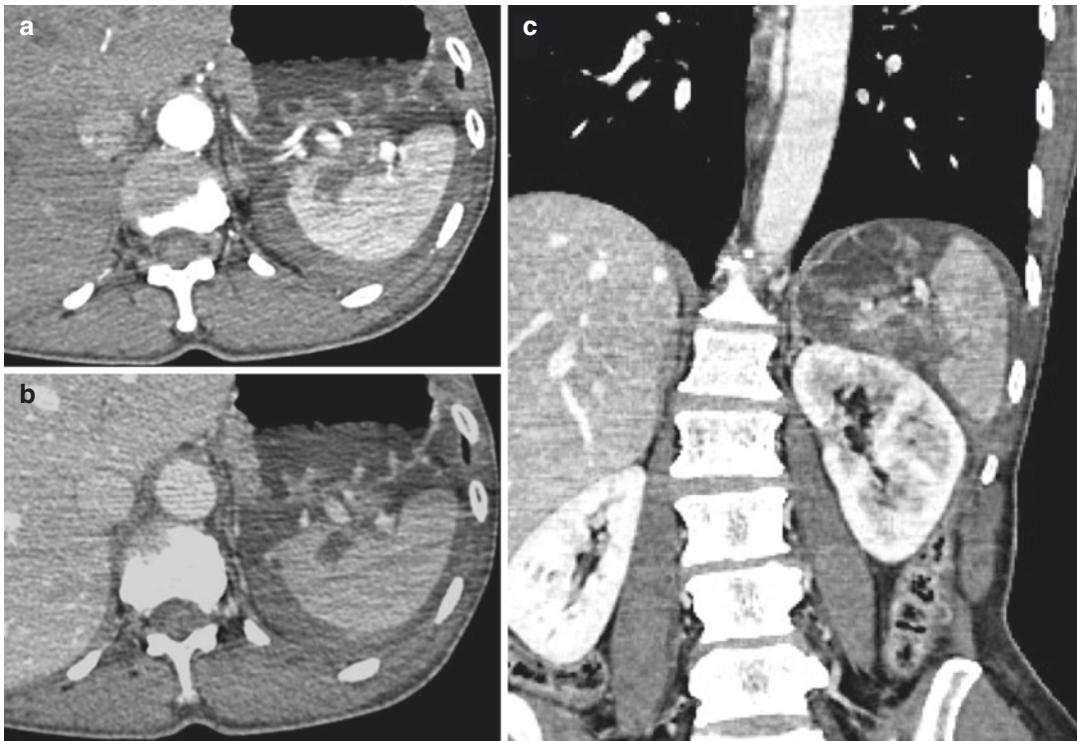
Grade 3: These CT images show a deep hilar splenic laceration with rupture of the capsule. Multiphasic CT scans in arterial (a-c) and venous phase in (b)
